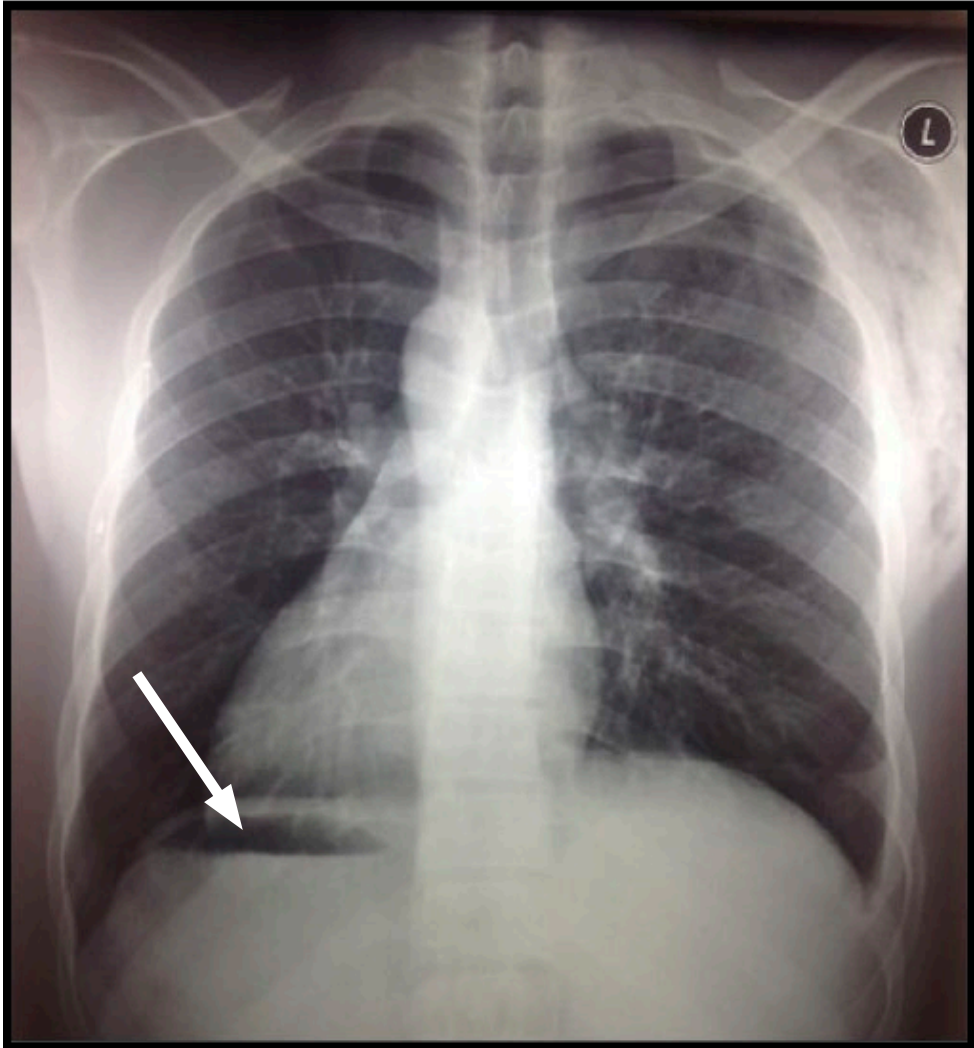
Chest X-ray (posteroanterior view) showing heart in the right hemithorax and the gastric bubble on the right (white arrow).
